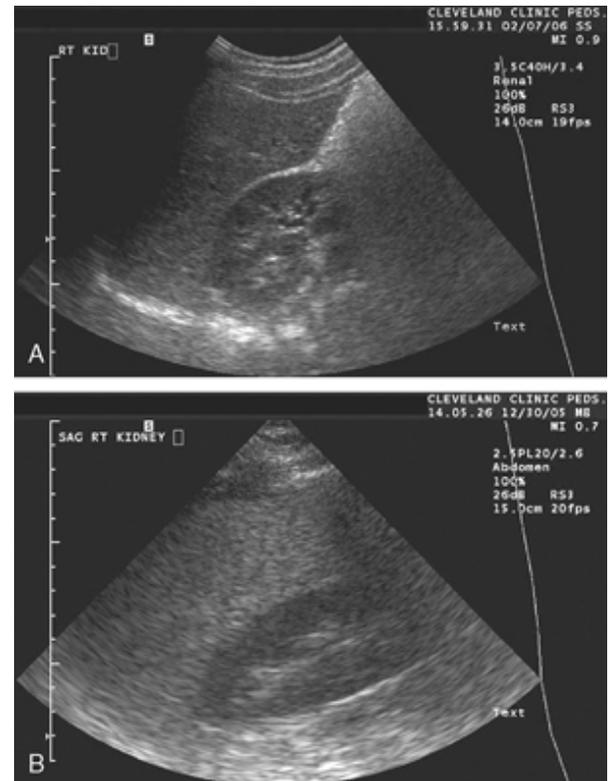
Sonographic features of normal liver (A) show same echogenicity as the kidney while fatty liver (B) shows increased echogenicity compared with the kidney. (34)
